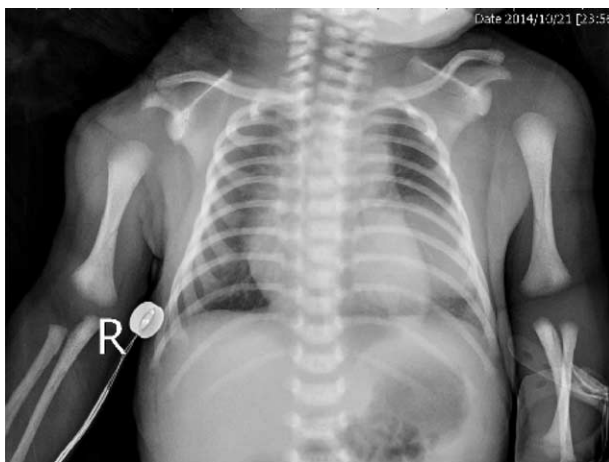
Chest x-ray demonstrated a mass-like opacity (3.3×2.8 cm) in the left lower lung. There were diffuse interstitial infiltrates in both the lungs, which suggested pneumonia.
